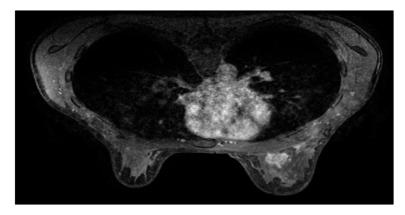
Breast MRI image showing a 2 cm malignant lesion close to the chest wall on the left side. By courtesy of Dr Anders Karlsson.
